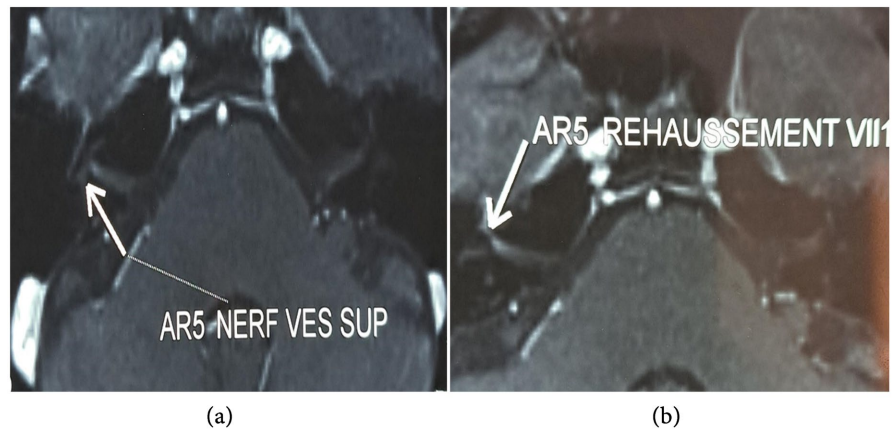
Axial view MRI of the temporal bone revealing contrast enhancement of the right superior vestibular nerve (a) and the first intrapetrous segment of the right facial nerve (b).
